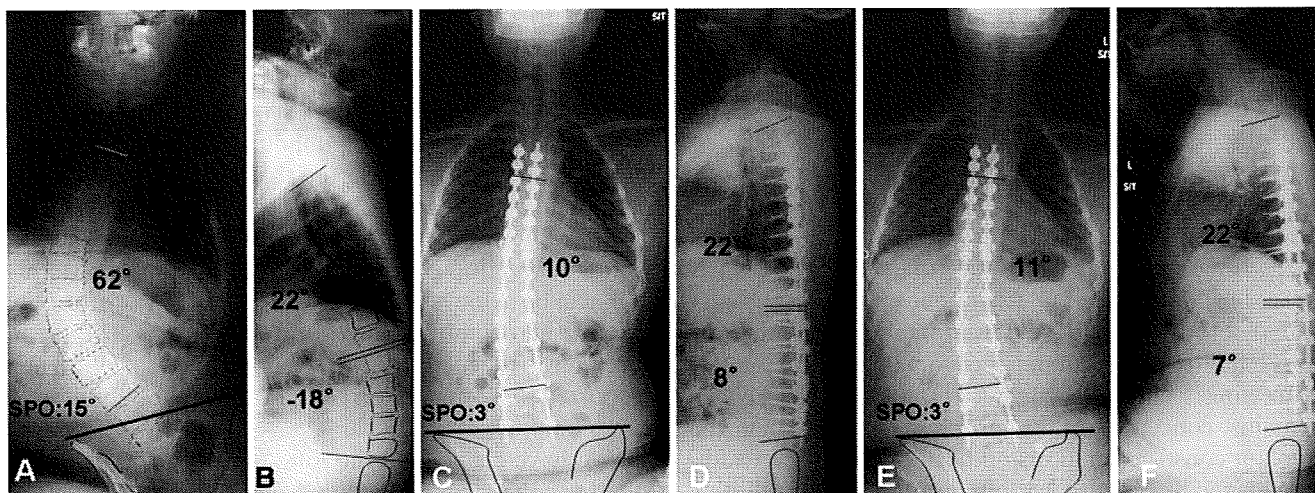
A, B Radiographs of a 13-year-old boy. Sitting anteroposterior preoperative radiograph demonstrates a significant thoracolumbar curve of 62° from T5 to L4. The pelvic obliquity was 15° . Lumbar kyphosis is present. He reported back pain and difficulty sitting before surgery. C, D Postoperative radiographs at 1 week after surgery. Significant initial coronal curve correction was obtained; and the lateral radiograph
